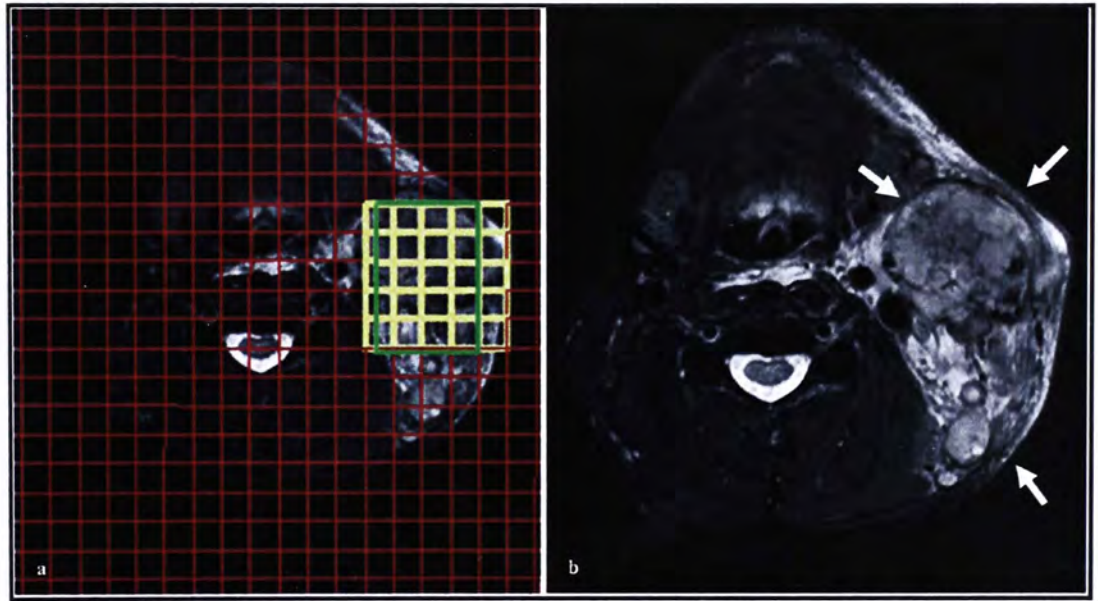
MRI images of a 53-year-old patient with NPC node (subject 3).
